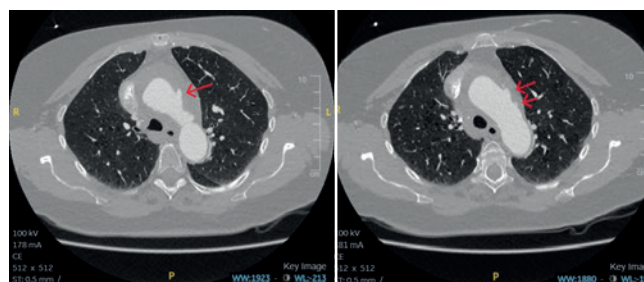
CT Aorta axial cut showing the outpouching
